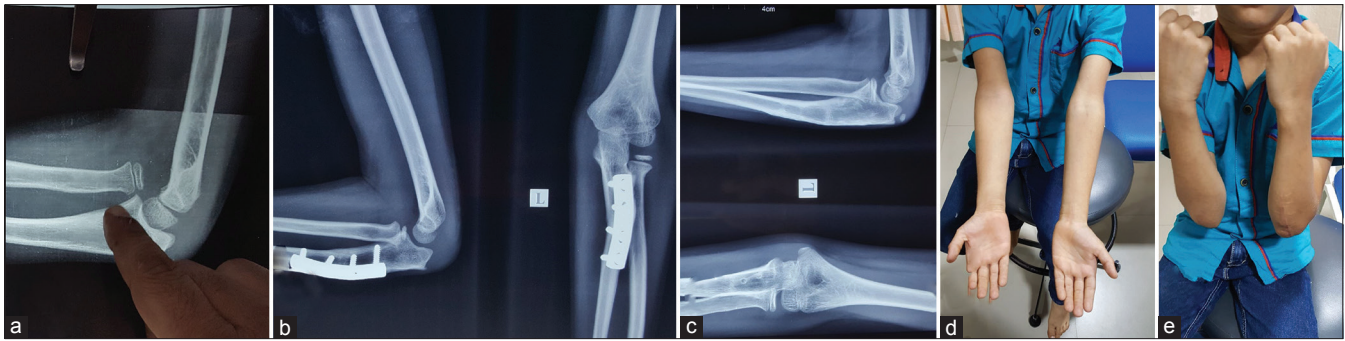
(a) Preoperative X-ray, (b) post-operative X-ray at 1-year followup, (c) 2-year followup, (d and e) range of movement at 2-year followup
